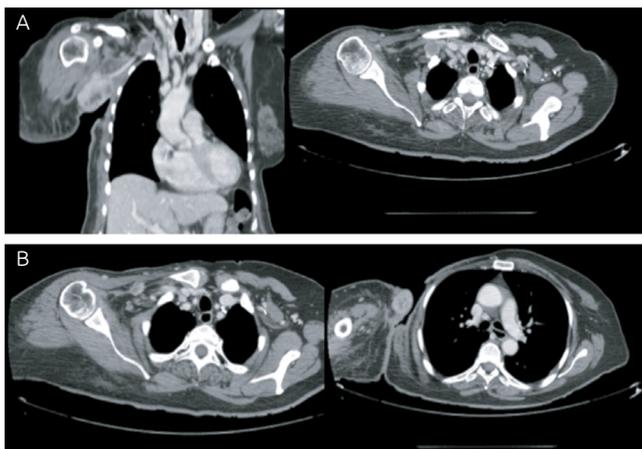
Chest computed tomography (A) pre-treatment; (B) after breast lesion resection with minimal residual extrathoracic disease.
